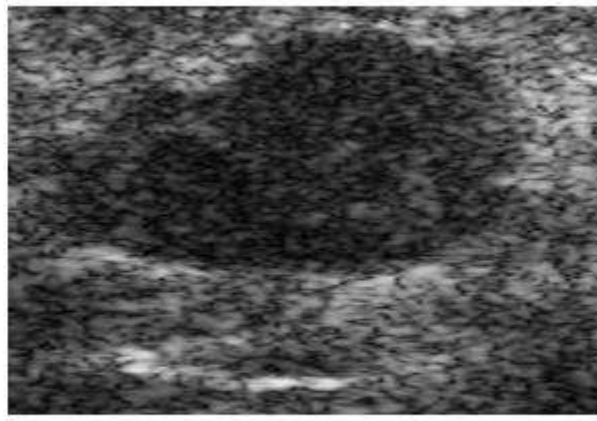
Ultrasound Image (Original Image)
